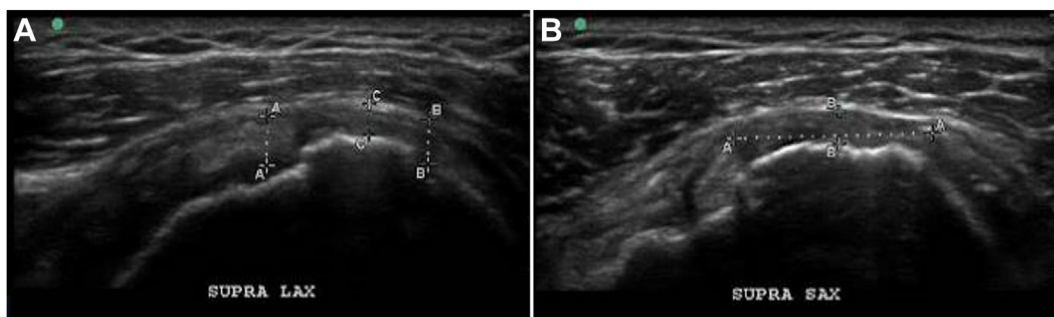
(A and B) US images of the supraspinatus from Case 1. (A) US images of the supraspinatus long-axis measurement view from Case 1. (B) US images of the supraspinatus short-axis measurement view from Case 1. US, ultrasound.
